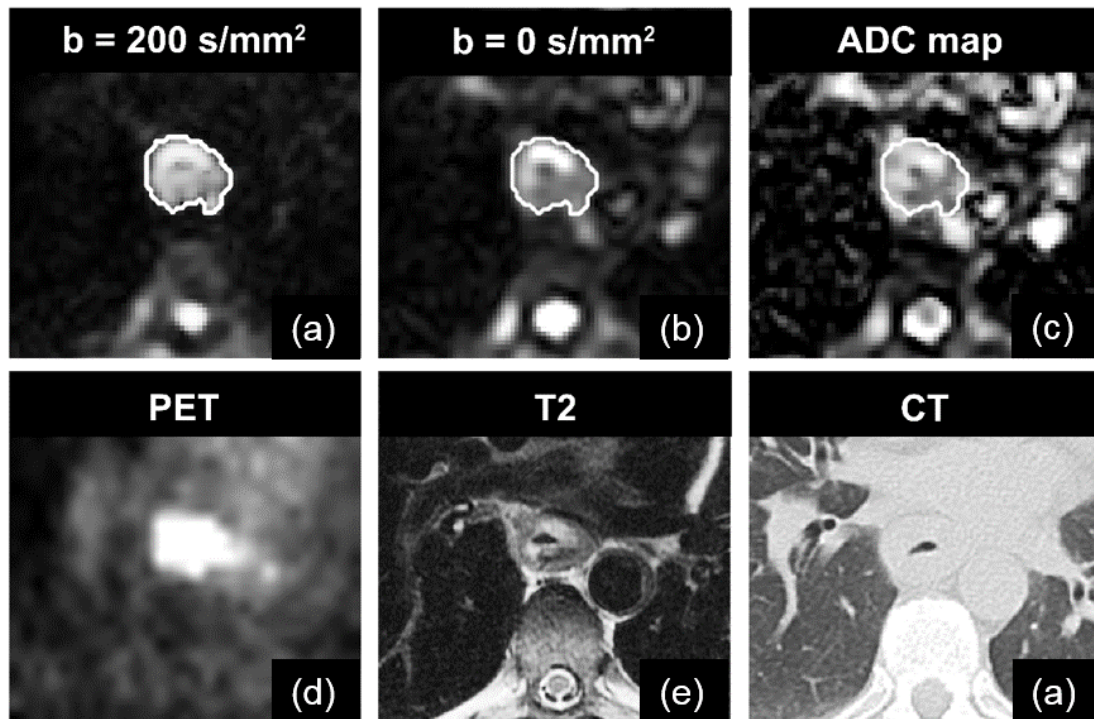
Diffusion images (a, b) and ADC map (c) from MONO exam of a patient at BL. Contours made on b100 are overlain on the image in white. FDG-PET (d), T₂-weighted image (e), and CT (f) images of the approximate slice are included for comparison.
